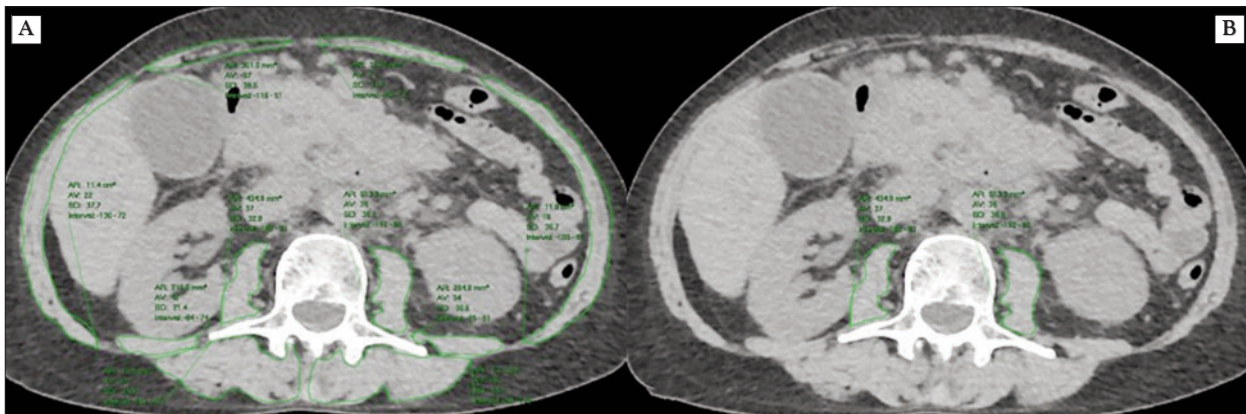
Native axial CT images demonstrating SMI values of 25.56 cm²/m² (A) and PMI values of 3.27 cm²/m² (B).
